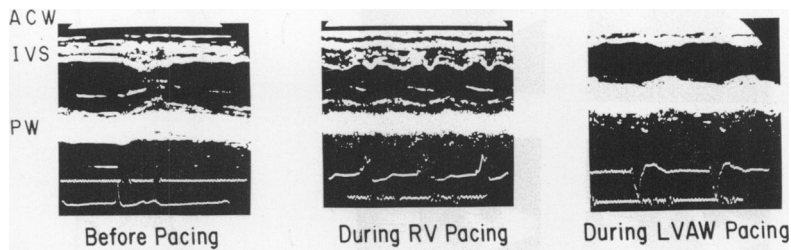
Echocardiograms before and during right ventricular (RV) pacing and the epicardial pacing of the left ventricular anterior wall (LVAW) in a patient with complete AV block. Echocardiograms before pacing and during LVAW pacing showed almost normal septal motion and that during RV pacing showed abnormal septal motion of type B.
